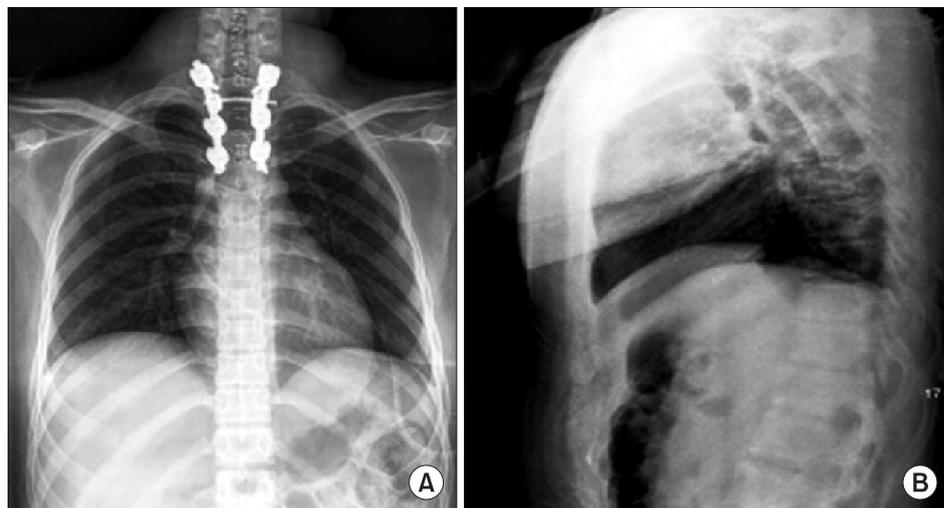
Plain radiographs, 2 days after the operation. (A) Anterior-posterior view, (B) lateral view.
